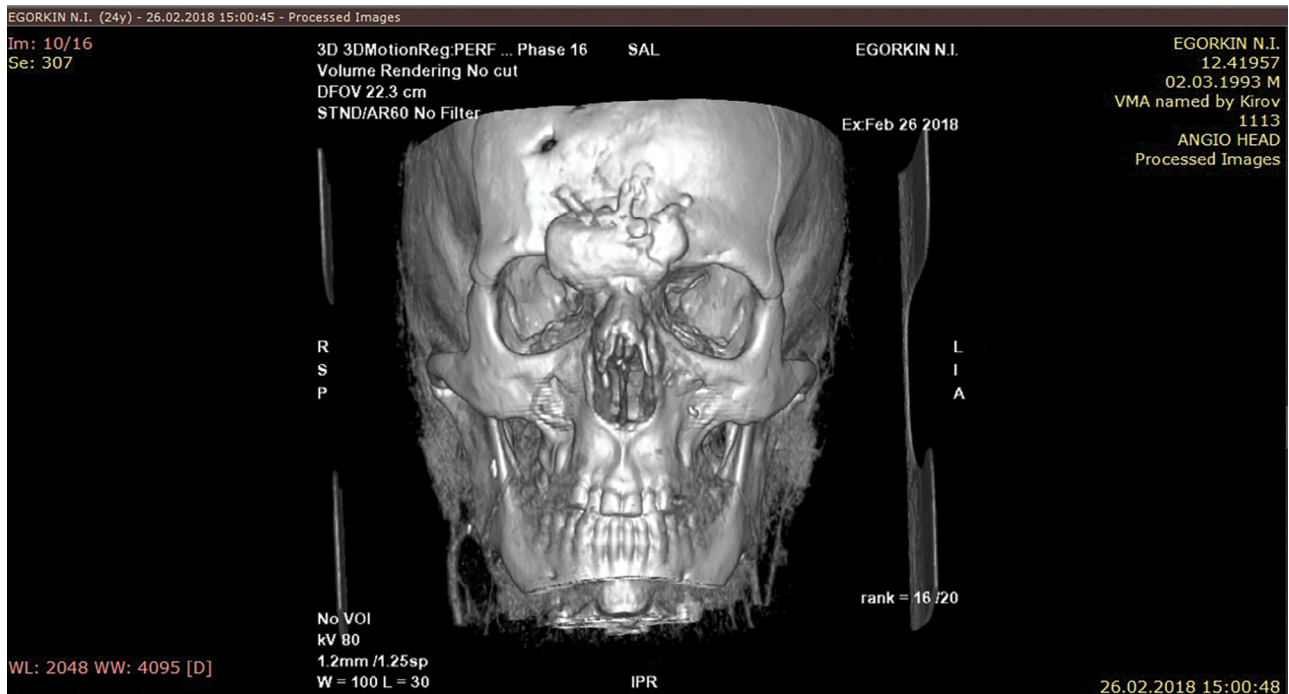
Computed tomography (CT) of the facial skull bones 33 months after the facial allotransplantation surgery.
